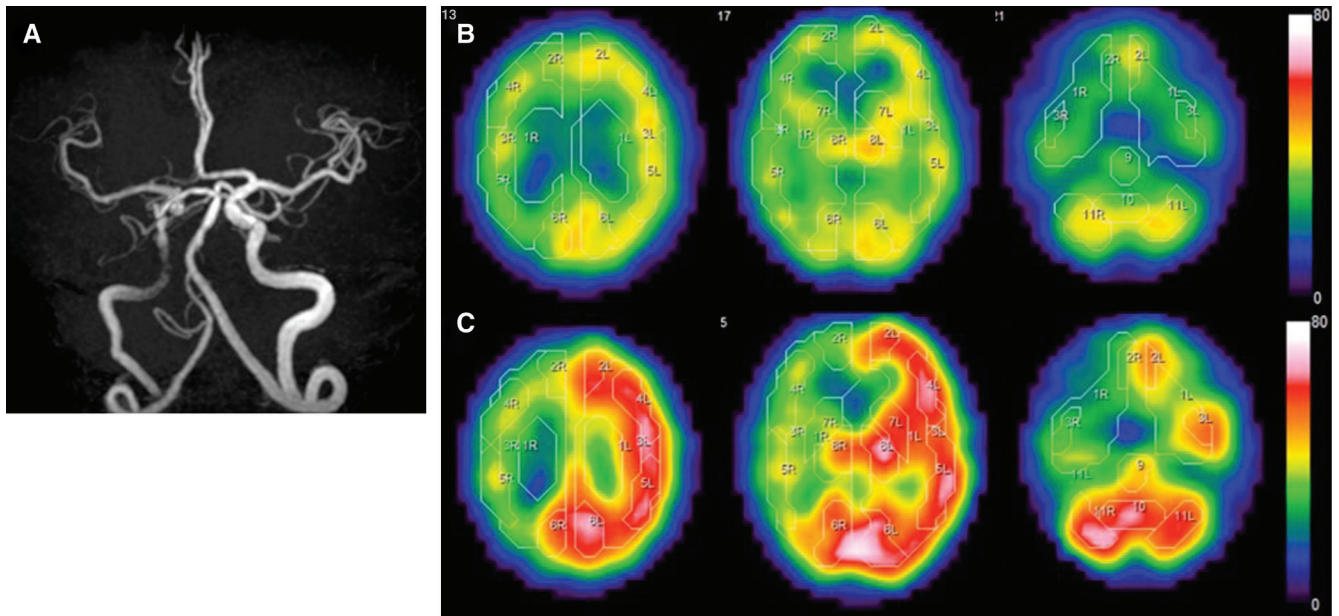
Findings of magnetic resonance angiography and SPECT before intracranial stenting. (A) Magnetic resonance angiography performed 9 months after the first surgery, showing low intensity of the right ICA. (B) N-isopropyl-p-[¹²³I] iodoamphetamine SPECT performed before the second surgery demonstrating a slight decrease in the right hemispheric CBF at rest (87% of that of the contralateral hemisphere) and (C), demonstrating a significant decrease in CVR after administration of acetazolamide (1.8% vs. 53% in the contralateral hemisphere). CBF: cerebral blood flow; CVR: cerebrovascular reactivity; ICA: internal carotid artery; SPECT: single-photon emission computed tomography.
